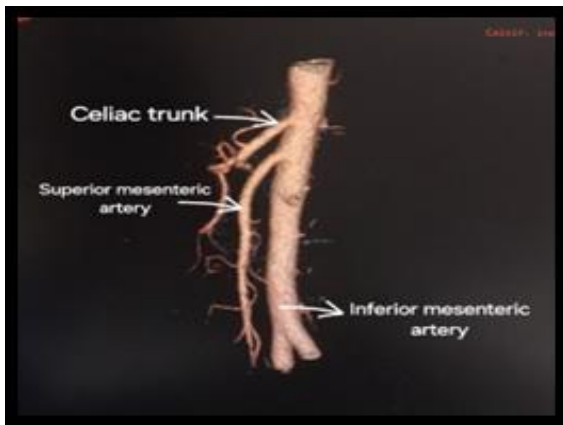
Computed tomography arterial phase images showing classical celiac trunk configuration (Uflacker's type I) with classical branching patterns of superior mesenteric artery and inferior mesenteric artery, (A) as viewed from front, (B) as viewed from lateral side
